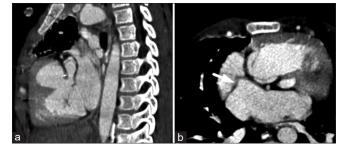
Pulmonary artery stenosis and cor-triatum dextrum. (a) sagittal computed tomography (CT) pulmonary angiogram image showing focal short-segment luminal narrowing at the origin/infundibulum of the main pulmonary artery. (b) axial CT pulmonary angiogram image showing a septum (arrow) separating the right atrium into two chambers
